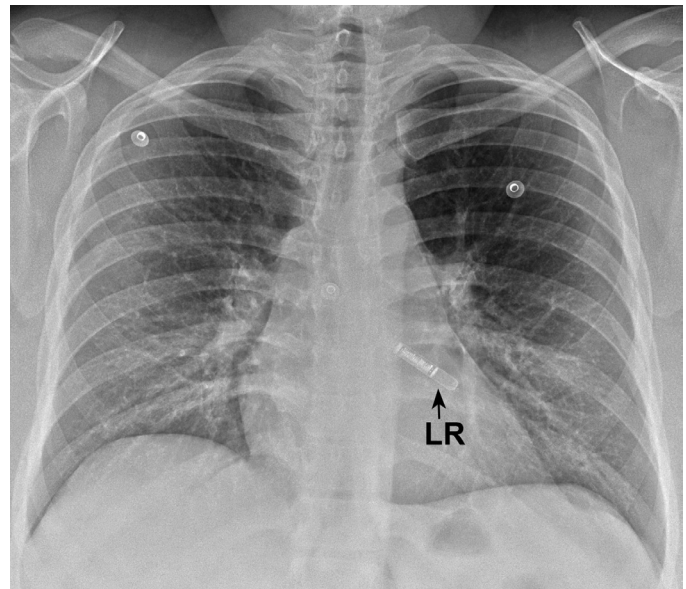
■ Posteroanterior (PA) chest x-ray. Implantable loop recorder (LR) is in the soft tissues of the anterior left chest wall.
